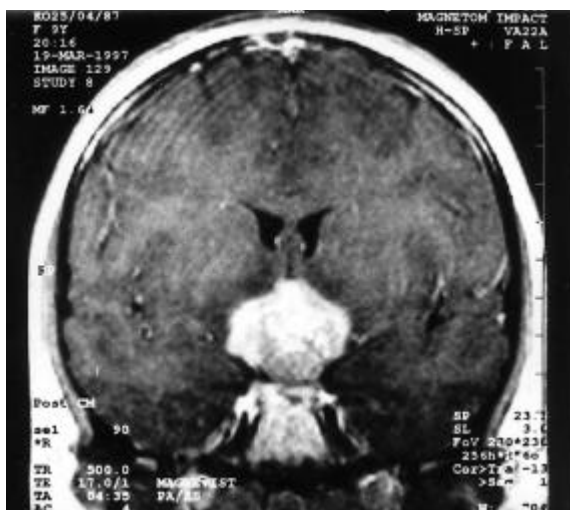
Diagnostic MRI (frontal section) demonstrating a midline mass in intra- and suprasellar region
